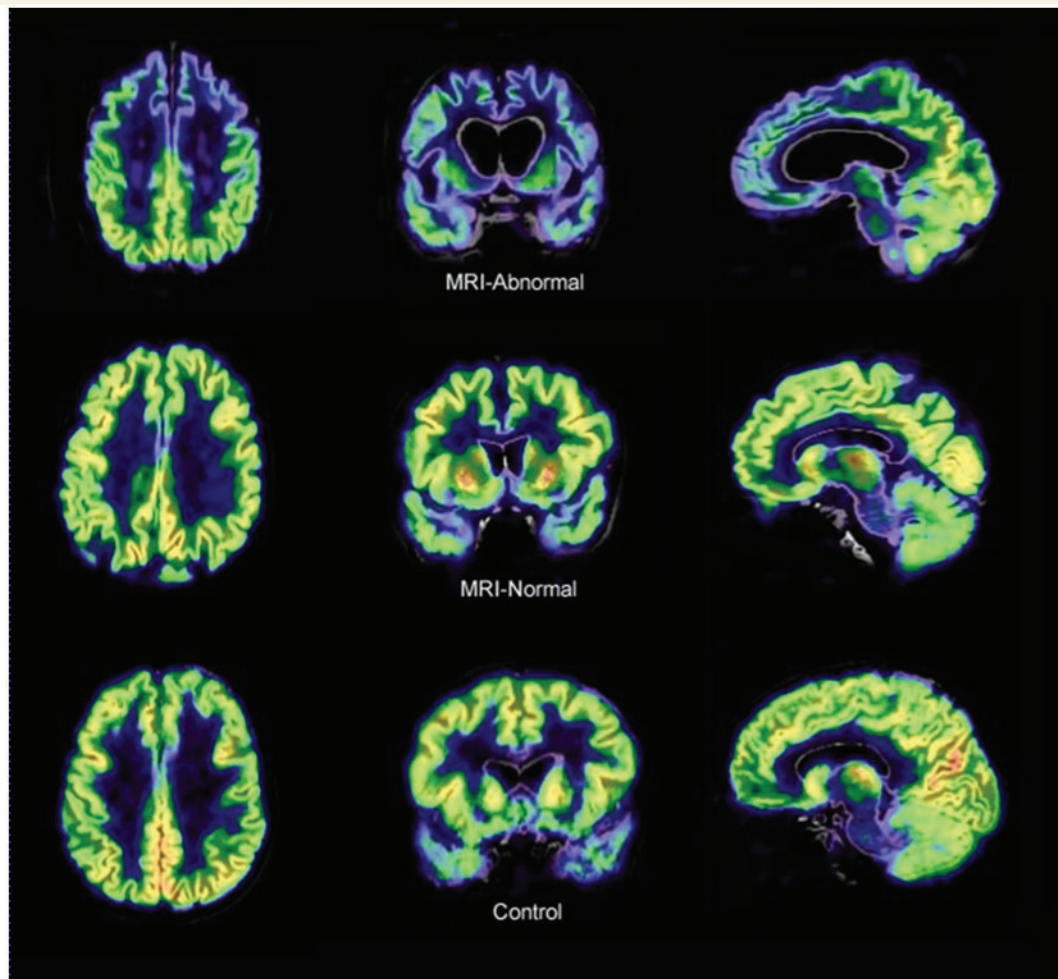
Coregistered MRI and PET images for representative behavioural variant frontotemporal dementia (MRI-Abnormal), behavioural variant frontotemporal dementia-phenocopy (MRI-Normal) and control subjects. Images are scaled according to colour bar on left, and show clear frontotemporal hypometabolism in behavioural variant frontotemporal dementia relative to both the phenocopy and controls which do not differ from each other.
